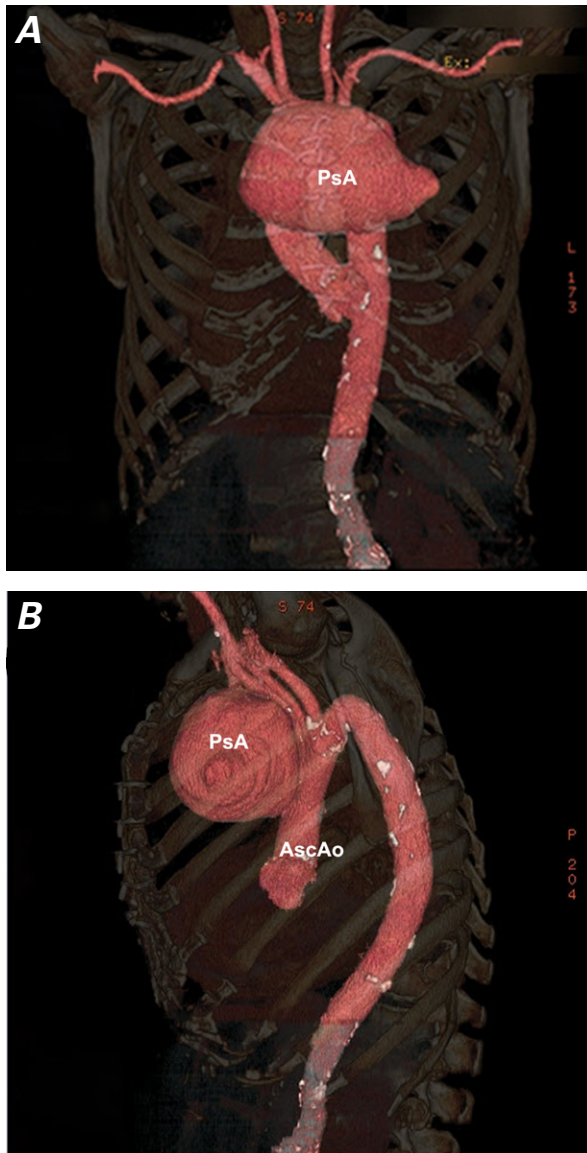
Contrast-enhanced computed tomograms (3-dimensional reconstruction) show a large pseudoaneurysm of the ascending aorta in A) coronal and B) sagittal views.
